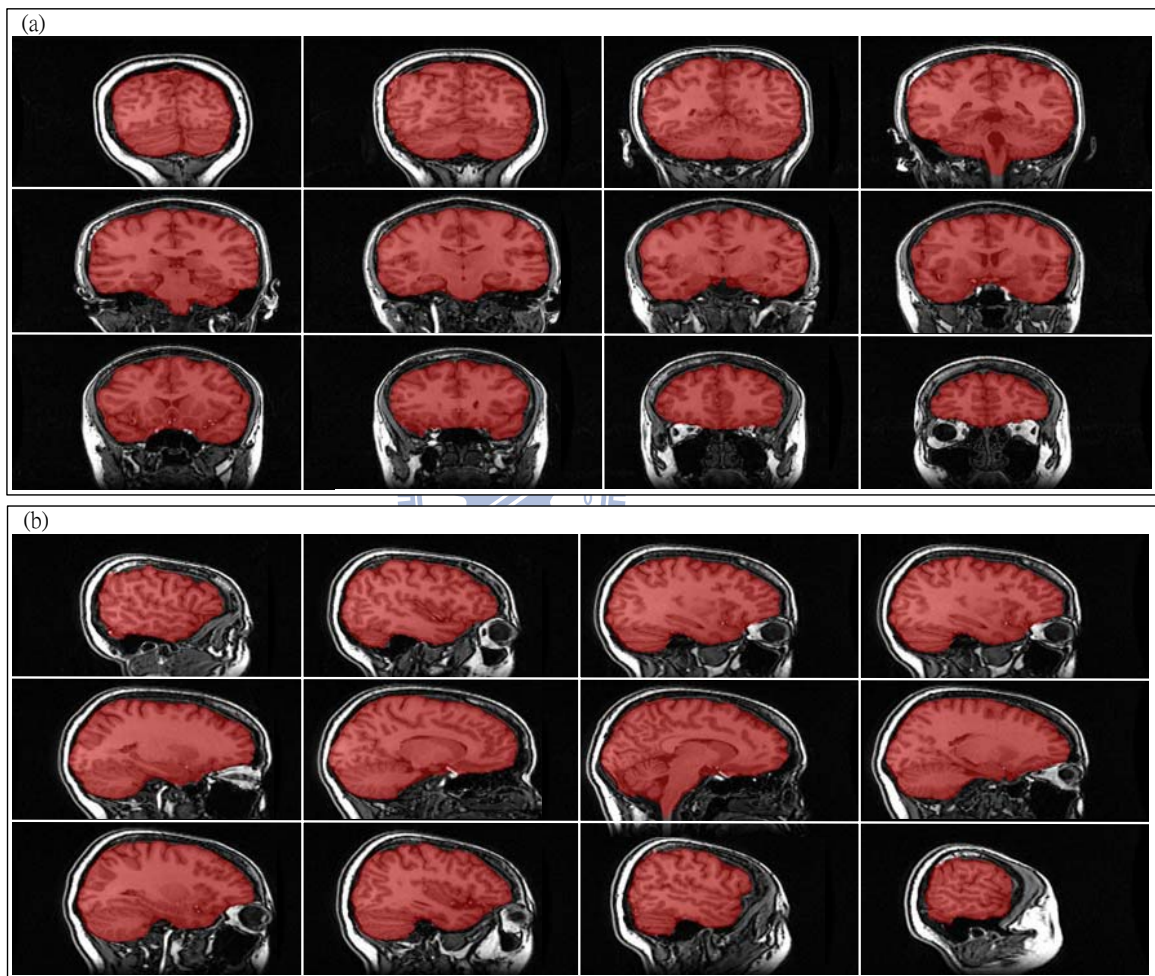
Brain extraction results of a T1-weighted image shown in (a) coronal and (b) sagittal views.
